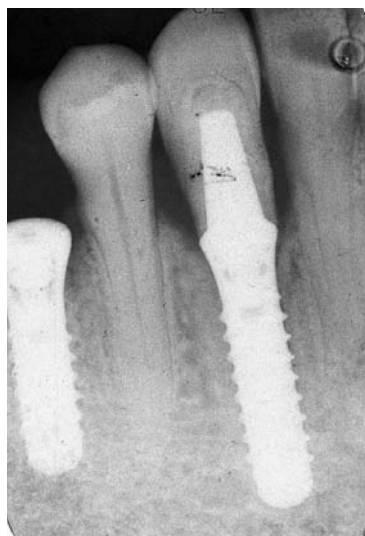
Radiograph at 2 months postoperative.
